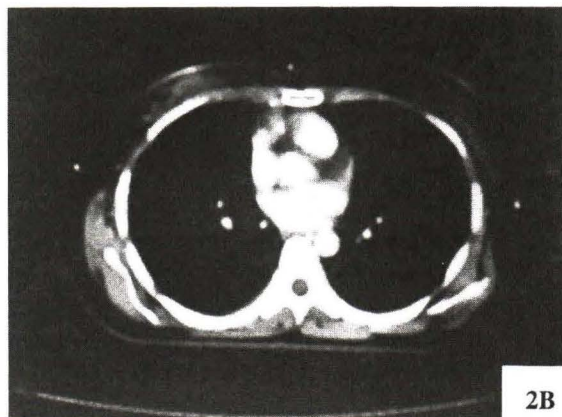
Axial CT scan 6 months after treatment, the tumor disappeared without any lung reaction detectable.
